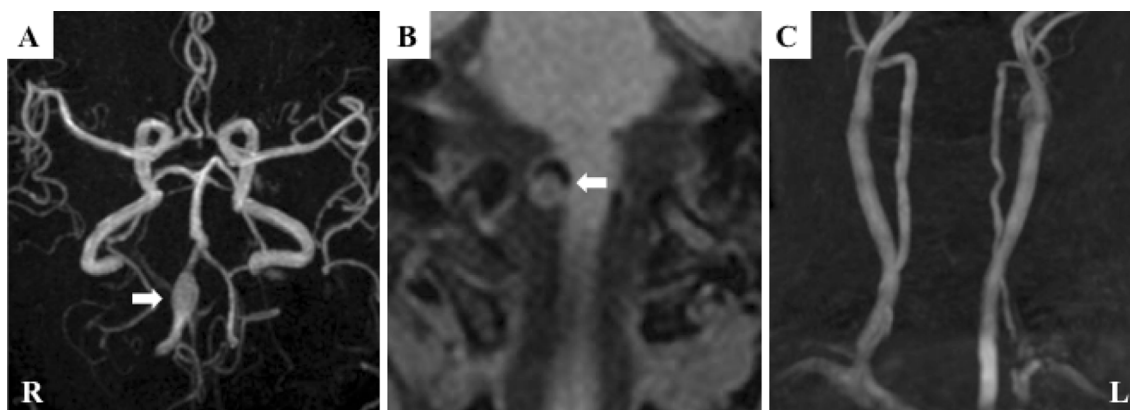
Cranial and cervical magnetic resonance angiography (MRA) and MRI. Cranial MRA 15 days after the clinical onset revealed aneurysmal dilatation of the intracranial segment of the right vertebral artery (arrow) (A). Intramural hematoma was detected in the wall of the affected artery (arrow) on T1-weighted imaging 35 days after the clinical onset (B). These findings suggest vertebral artery dissection. On cervical MRA 35 days after the clinical onset, no abnormality was found in the extracranial portion of the vertebral artery (C).
